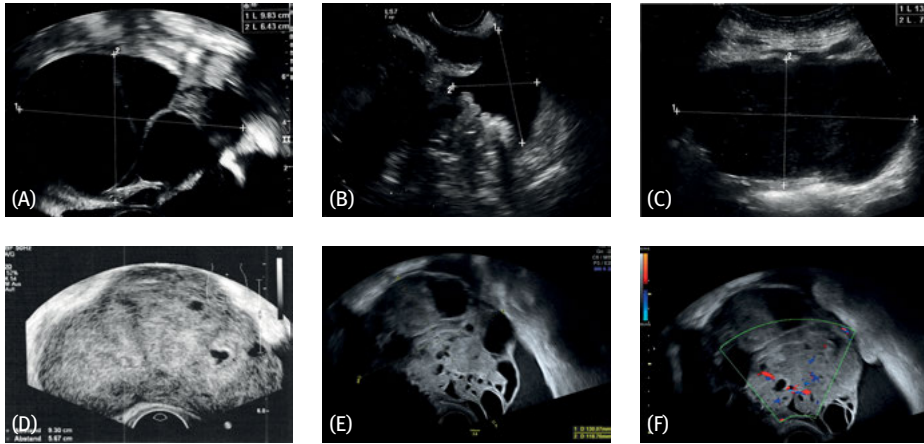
Ovarian carcinosarcomas in sonography. (A)–(C) This tumor, that was equally pleomorphic on gross observation, exhibits all of the distinguishing features of carcinosarcoma in the different sectional planes, that can however also be found in ovarian carcinoma: predominantly cystic elements with septa of differing thickness (A), solid components with papillary growth into the cysts (B), extensive necroses with dull/weak echogenicity (C); (D) predominantly solid hyperechoic ovarian carcinosarcoma; (E) mixed solid-cystic carcinosarcoma, the solid components are hyperechoic, some of the anechoic voids constitute vessels, the cysts were also easy to discern macroscopically; (F) color Doppler sonography of (E) with noticeably irregular perfusion of the solid tumor components/septa.
